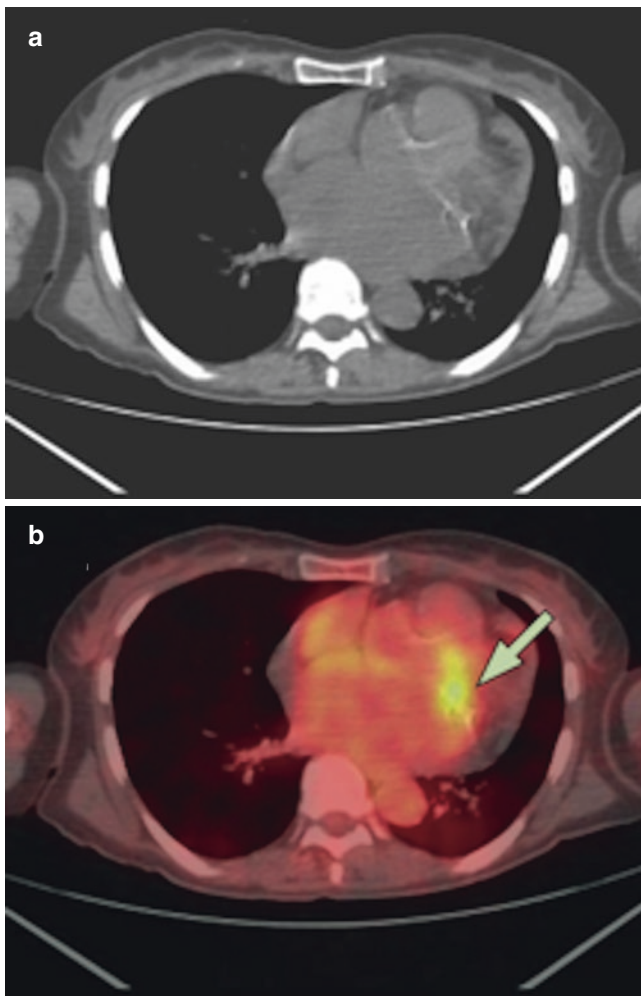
PET-CT of a 64-year-old woman with a mass on thickened mitral valve but no pathogen identified by blood cultures or serology. *FDG* fluorodeoxyglucose. (a) Transaxial CT scan. (b) Transaxial PET-CT fused image showing an increase *FDG* uptake in the area of the mitral valve (green arrow). The endocarditis diagnosis was confirmed by pathological examination after surgery (recurrent emboli) showing vegetation but no pathogen could be identified. From Thuny F, Grisoli D, Collart F, Habib G, Raoult D. Management of infective endocarditis: challenges and perspectives. *Lancet*. 2012;379(9819):965–75. Reproduced with permission from Elsevier Limited
